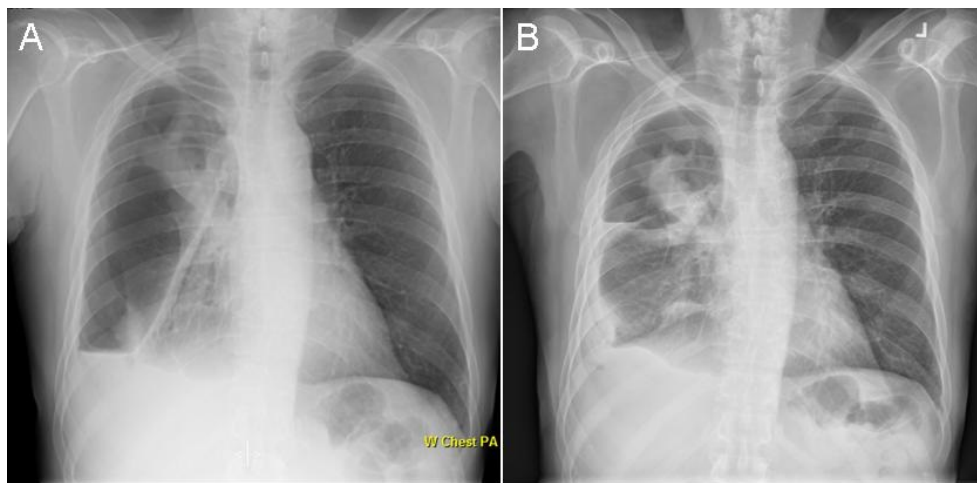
Panel A: original chest radiograph. Panel B: repeat chest radiograph about 1 week after endobronchial valve insertion.
